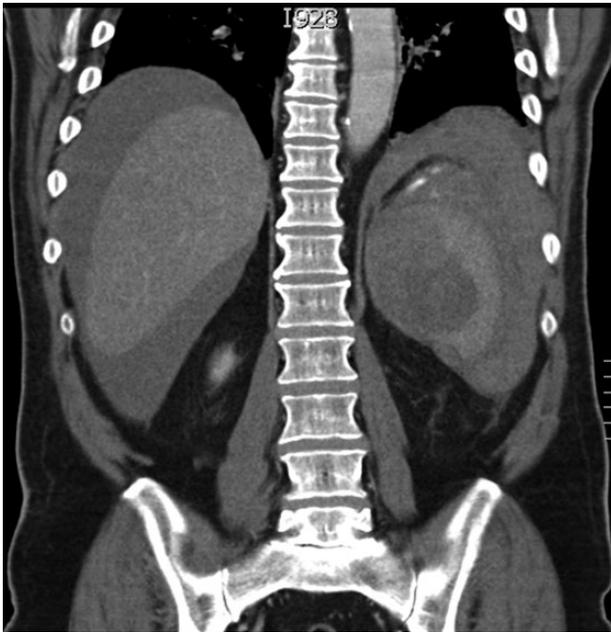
Coronal section of the CT scan showing the abnormal spleen and the haemoperitoneum.
